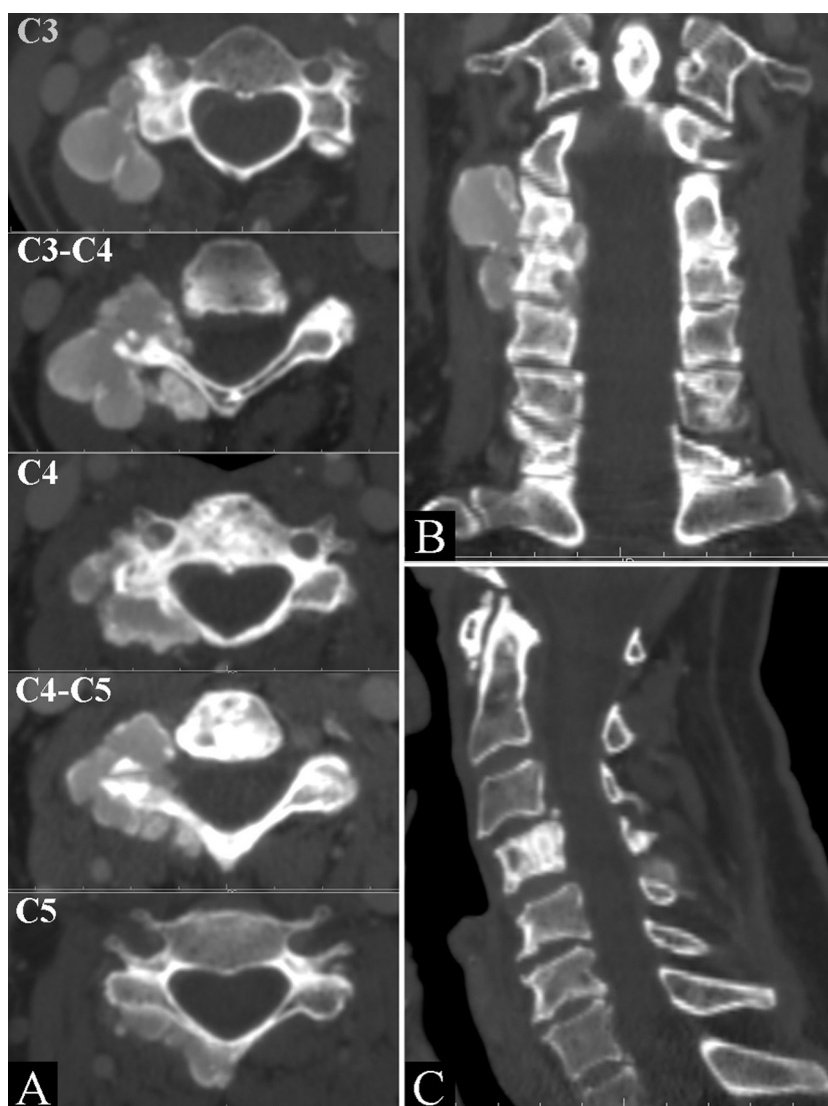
Axial CT scans (A) and coronal reconstruction (B) show lobulated partially calcified masses with sclerotic rim involving right facet joints and laminae of C3–C5 vertebrae. The masses narrow down the neural and transverse foramina also penetrate into the spinal canal at C3/C4 level. The sagittal reconstruction (C) show degenerative discs disease and anterior dislocation of C3; the C4 vertebral body appears sclerotic.
